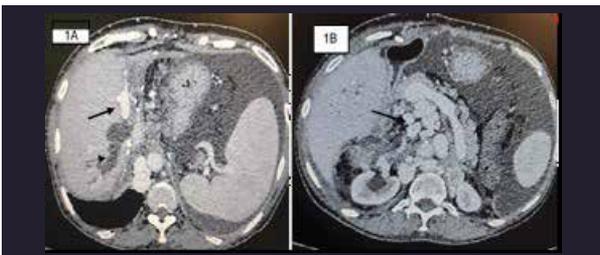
1A-Contrast enhanced CT (Porto venous phase) showing dilated posterior segmental biliary duct (small black arrow) and vertical angulation of anterior segmental portal vein (black arrow) with 1B image showing dilated retroperitoneal and mesenteric collaterals (black arrow)
